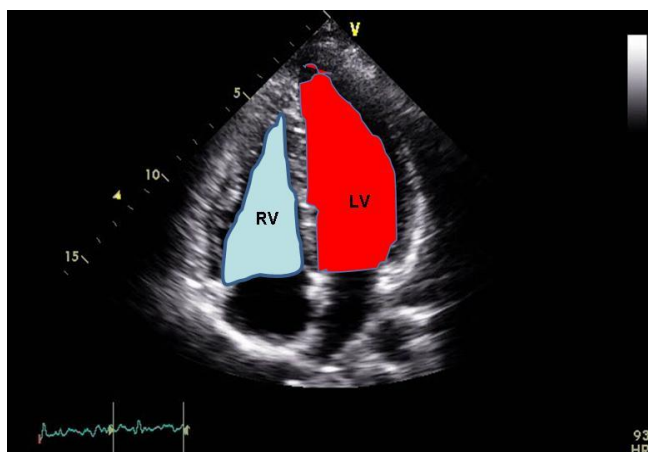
Apical 4-chamber view showing comparison of RV and LV end-diastolic areas.
